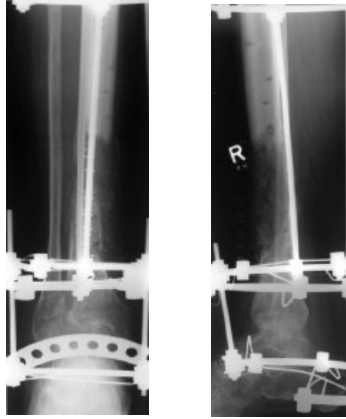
12-weeks postoperative radiographs showing removal of chain and filling with 15ml of NanoBone
